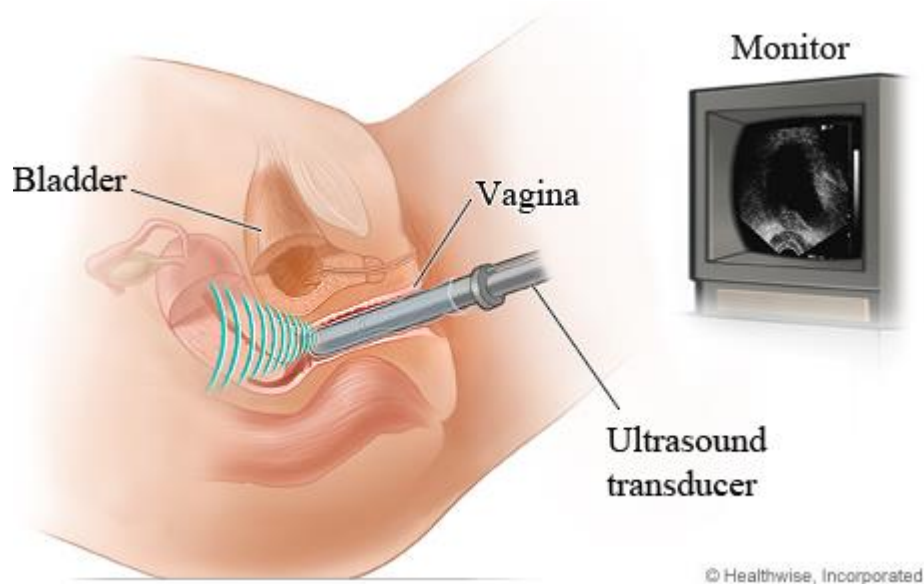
Transvaginal Ultrasound
